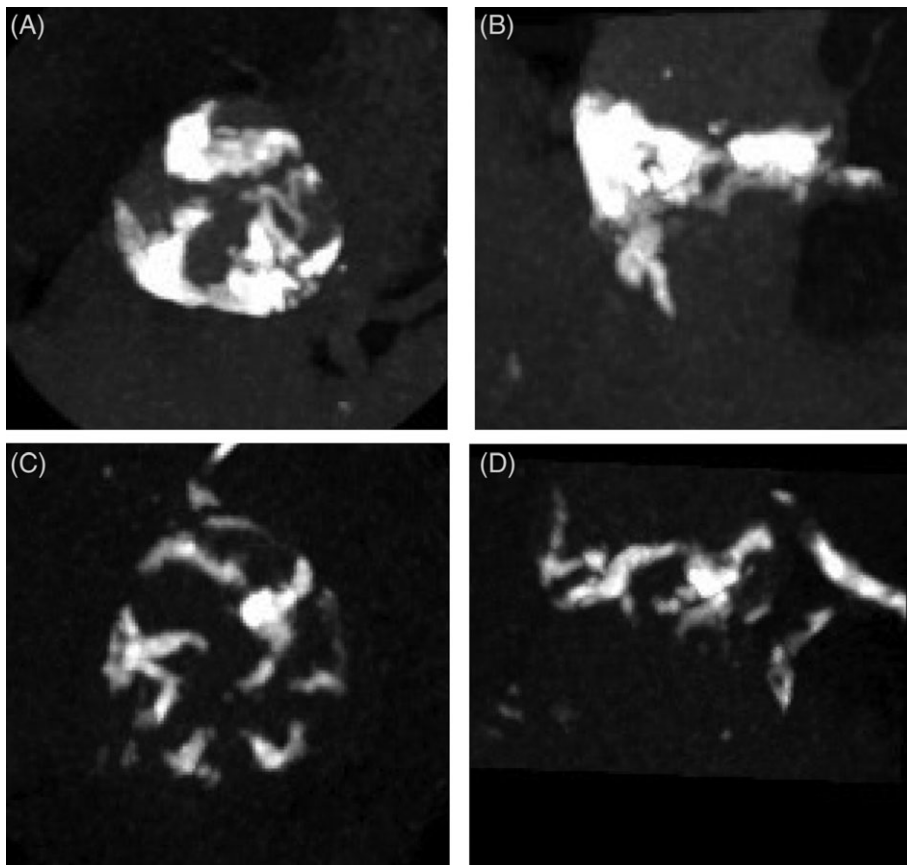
MDCT scan to detect the grade of calcification in patients with AS. (A,B) A severely calcified AS, in (A) short-axis view and (B) side view. (C,D) Mild to moderately calcified AS, in (C) short-axis view and (D) side view. Abbreviations: AS, aortic stenosis; MDCT, multidetector computed tomography.
